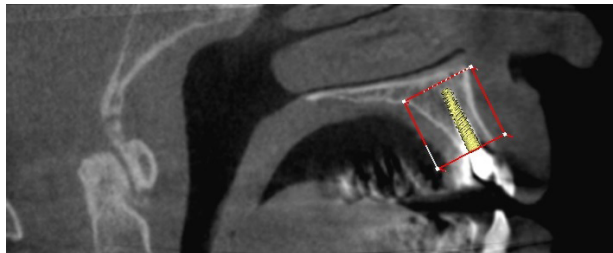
Last part of alignment done with MIRT to obtain the exact coordinates of the implant in the CBCT image.
